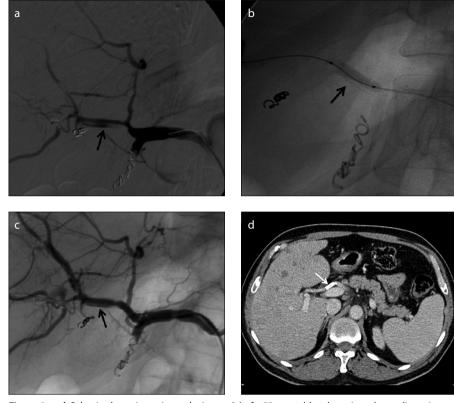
a–d. Selective hepatic angiography image (a) of a 55-year-old male patient shows dissection (*arrow*) of the right hepatic artery that occurred during transcatheter radioembolization of metastatic liver lesions and previously embolized cystic and gastroduodenal arteries. Angiography image (b) shows a balloon-expandable stent-graft (*arrow*). Control angiography (c) shows the stent-graft (*arrow*). Axial computed tomography angiography image (d) at 18-month follow-up shows a patent stent-graft (*arrow*).
